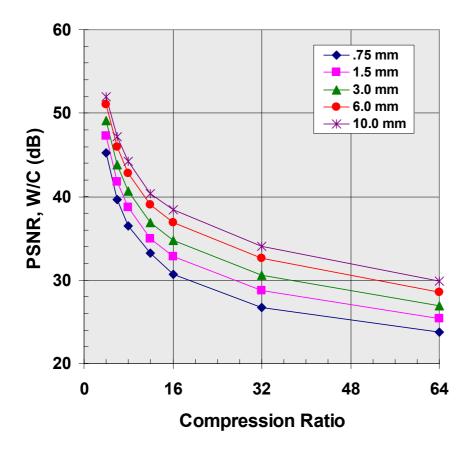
Thinner CT slices result in a lower peak signal to noise ratio at a given level of compression. This also suggests a greater level of distortion of thin slices and thus a lower level of compressibility than thicker slices. Unlike the JND curve in figure 2, there is not a substantial increase in the difference between the thin and thicker sections for high levels of compression in comparison to lower levels.
